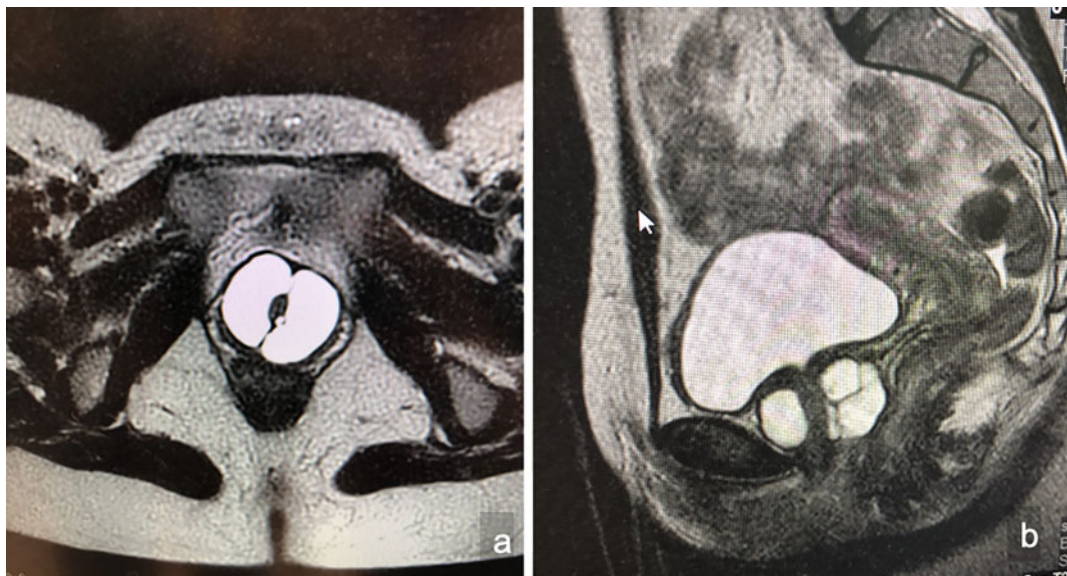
Complex urethral diverticulum on MRI (a: axial; b: sagittal)
